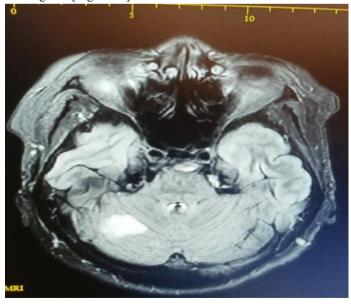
MRI brain (axial view) demonstrating subacute infarct in the right cerebellar hemisphere
